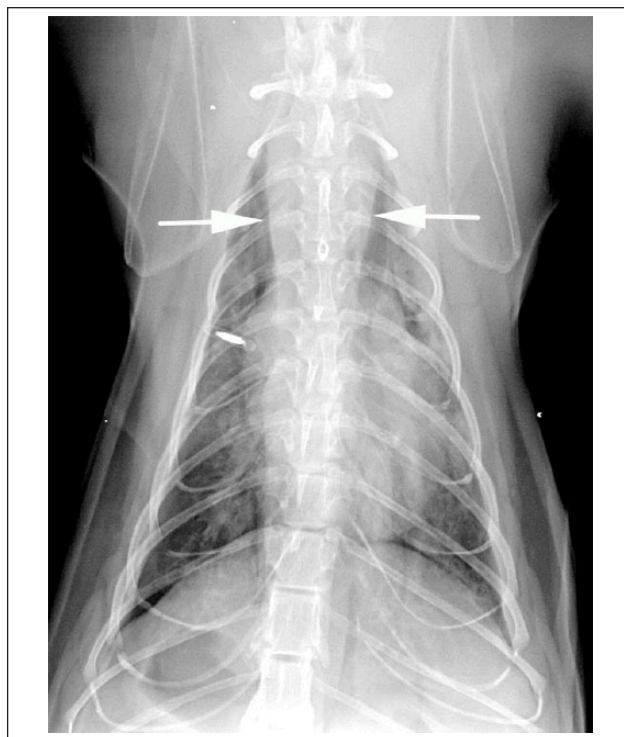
A dorsoventral radiographic view of the thorax under general anaesthesia. There is widening of the cranial mediastinum to greater than one vertebral body width (arrows). There is increased opacity of the cranial lung lobes with alveolar opacity and unstructured interstitial pattern in the remaining parenchyma
